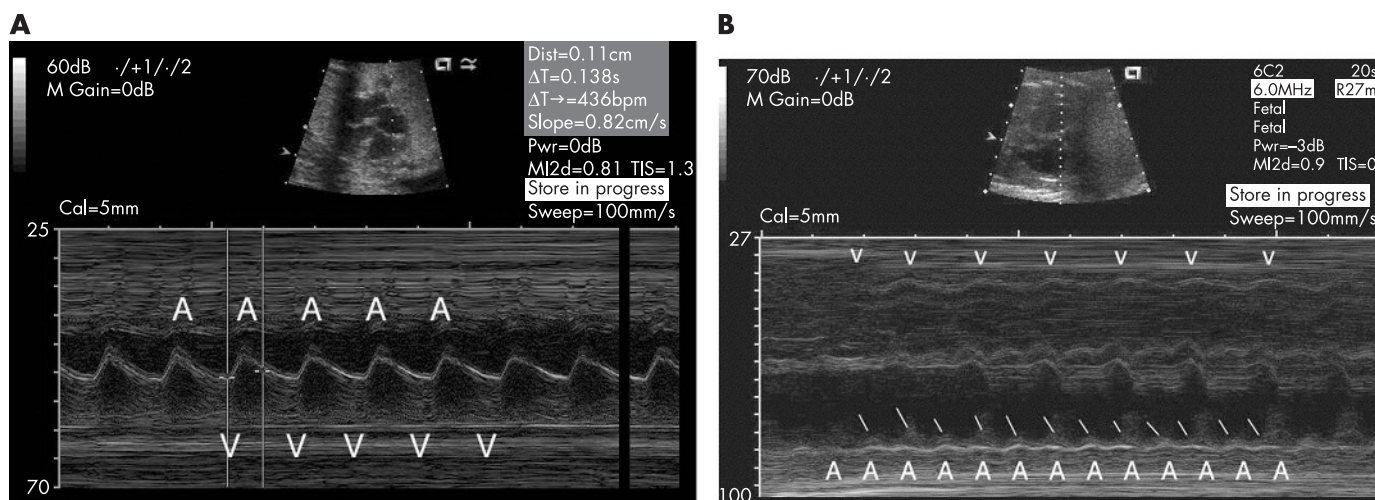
Examples of fetal supraventricular tachyarrhythmias as assessed by echocardiographic techniques. (A) This 25 week gestational age fetus had intermittent long ventriculo-atrial (V–A) supraventricular tachycardia at a rate of 230 bpm. The 1:1 atrioventricular (A–V) relationship is demonstrated by M mode (left), but the longer V–A relative to A–V relationship is more clearly defined by simultaneous superior vena cava–aorta (SVC–AO) Doppler (right). Postnatally a diagnosis of ectopic atrial tachycardia was confirmed. “A” denotes retrograde flow in the SVC during atrial systole and V denotes flow in the ascending aorta with ventricular systole. (B) This is an M mode tracing obtained in a 32 week fetus with incessant atrial flutter and significant cardiomegaly which was associated with an atrial (A) rate of 400 bpm and a ventricular (V) rate of 200 bpm.
